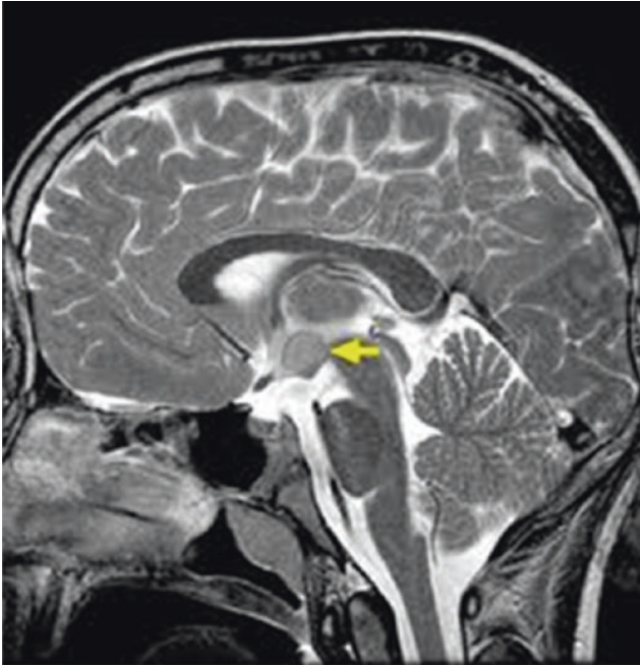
Magnetic resonance imaging of brain, sagittal view showing hypothalamic hamartoma (arrow)
